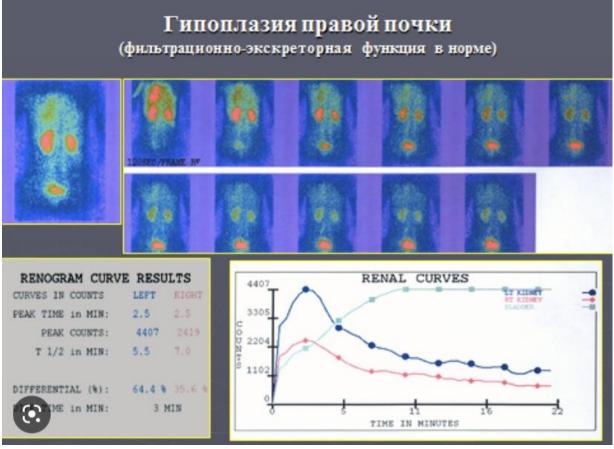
Diuretic scintigraphy Источник: <u>https://2gdkb.by/о-клинике/отделения/изотопная-лаборатория</u>)
